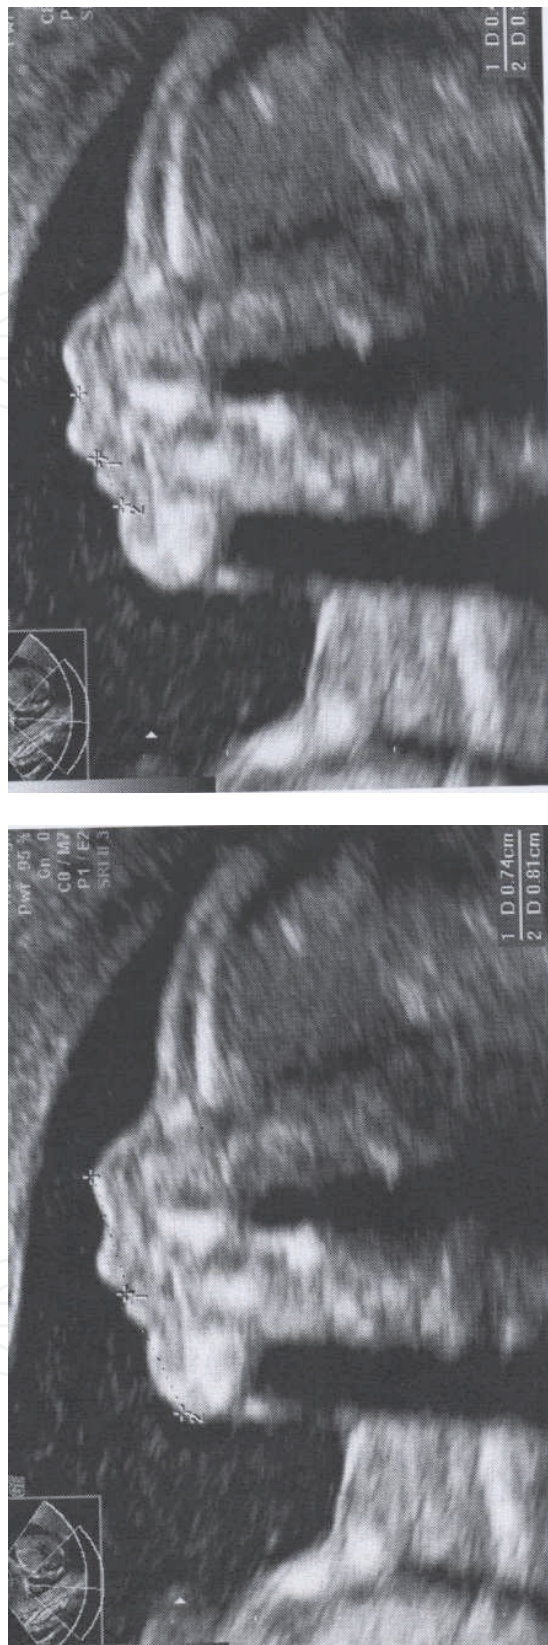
Sonographic picture of the fetal face. Typical facial concavities and protrusions are presented. The calipers measured between the upper philtrum to the mouth (upper picture), and between the mouth to the chin (lower picture).
